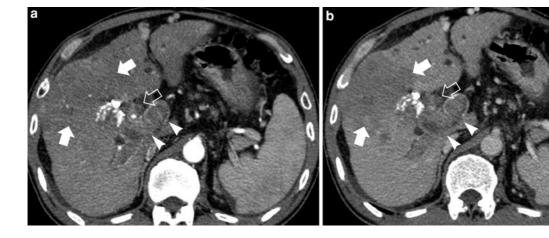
HCC with bile duct invasion and tumor thrombus in the portal vein. a Arterial phase CT scan shows a faintly enhancing HCC lesion (*arrows*) in right anterior segment with lipiodol and enhancing tumor thrombus in the bile duct (*open* (arrows)) and (arrows) in the bile duct (*open* (arrows)) is the bile duct (*open* (arrows)) in the bile duct (*open* (arrows)) is the bile duct (*open* (arrows)) in the bile duct (*open* (arrows)) is the bile duct (*open* (arrows)) in the bile duct (*open* (arrows)) is the bile duct (*open* (arrows)) in the bile duct (*open* (arrows)) is the bile duct (*open* (arrows)) in the bile duct (*open* (arrows)) is the bile duct (*open* (arrows)) in the bile duct (*open* (arrows)) is the bile duct (*open* (arrows)) in the bile duct (*open* (arrows)) is the bile duct (*arrows*) in the bile duc
